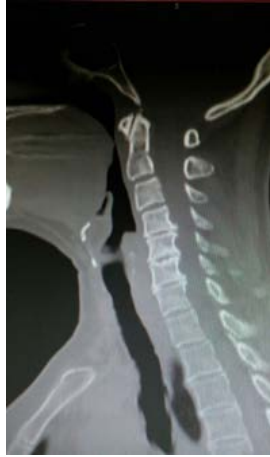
Preoperative sagittal computed tomography scan of C4-5, C5-6, and C6-7 level Herniopathy (HNP), osteophyte, and osteophyte.
